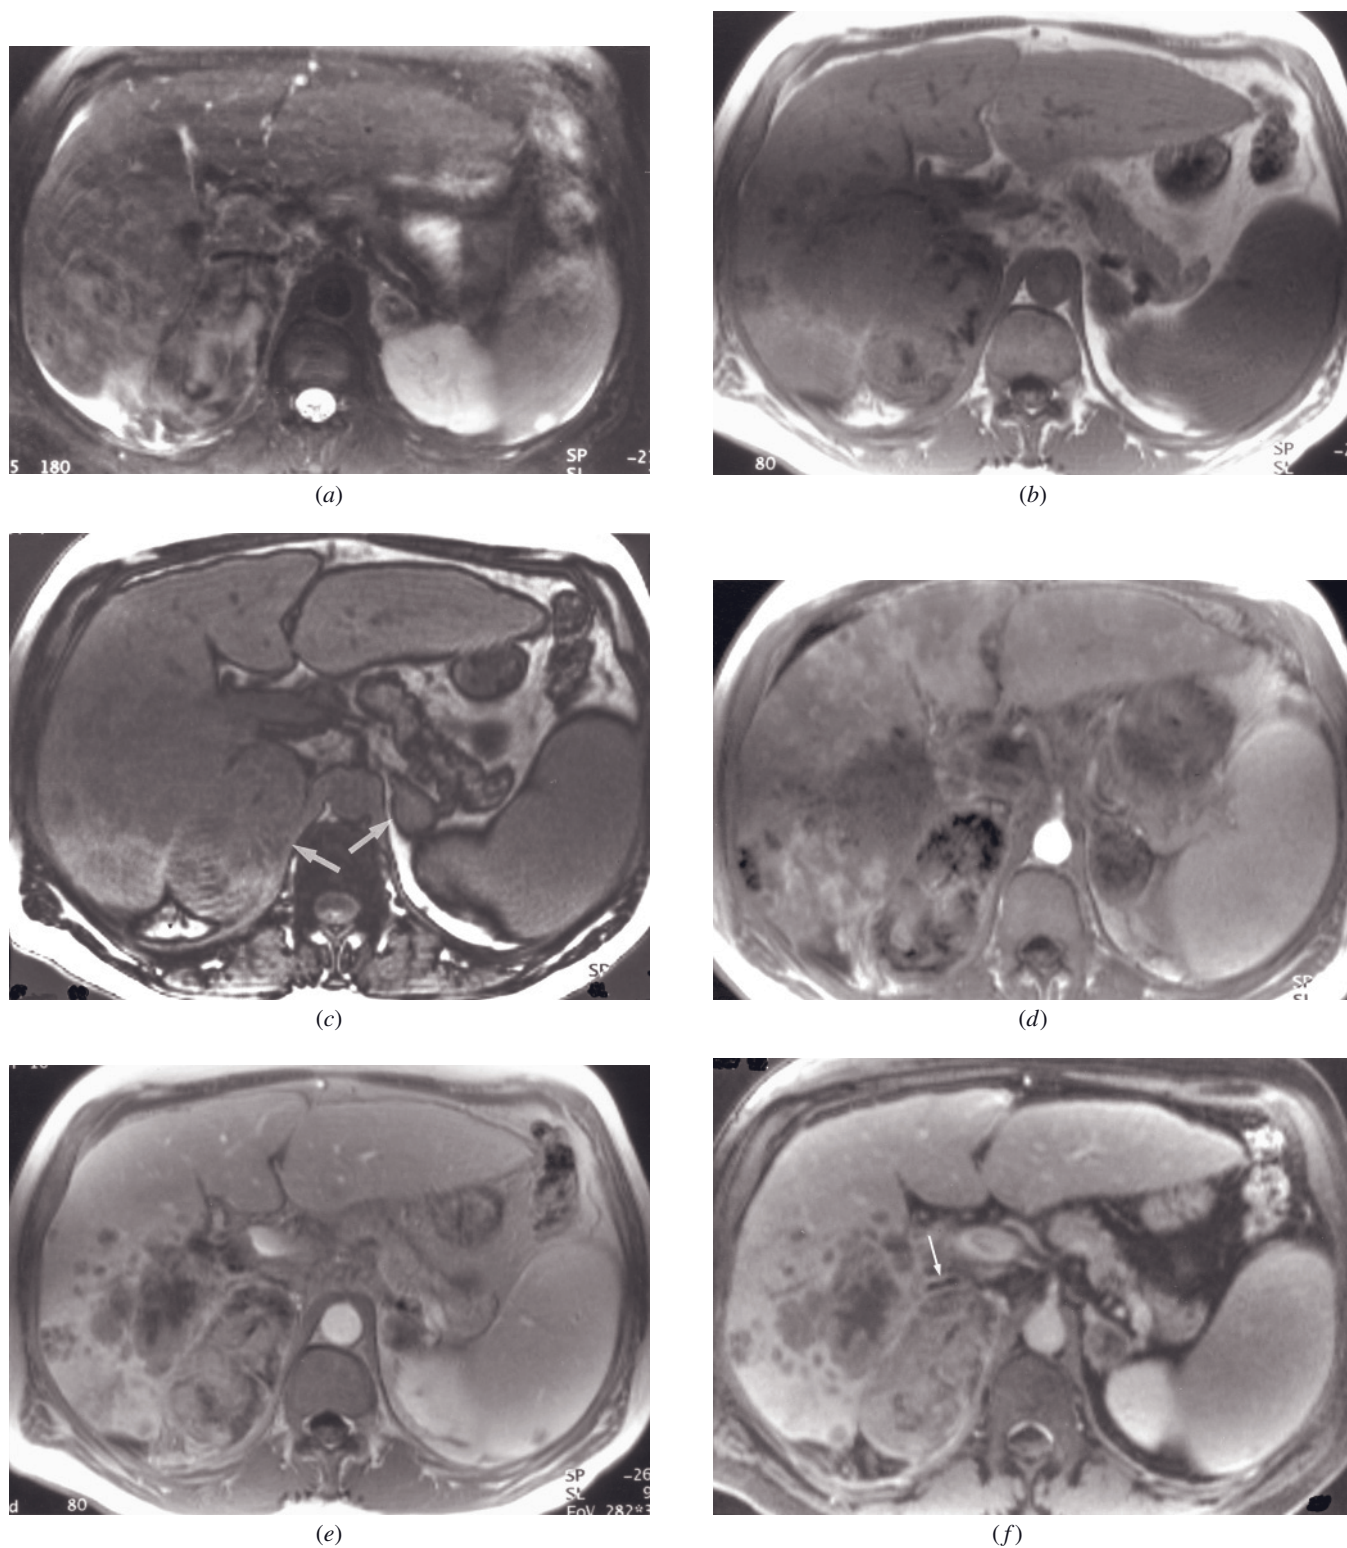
HCC and adrenal metastases. Fat-suppressed T2-weighted ETSE (*a*), SGE (*b*), out-of-phase SGE (*c*), and immediate (*d*), 45-s (*e*), and 90-s fat-suppressed postgadolinium SGE (*f*) images. There are multiple lesions throughout the liver, which are high signal on T2 (*a*) and low signal on T1 (*b*) and demonstrate a mixed population of lesions that enhance in a diffuse heterogeneous or peripheral ring fashion on immediate postgadolinium images (*d*), consistent with multifocal HCC. Ring enhancement in many of these lesions presumably represents intrahepatic metastases. Bilateral adrenal masses (arrows, *c*) are present that demonstrate mixed signal intensity on T1 (*b*), do not drop in signal on out-of-phase (*c*), and enhance heterogeneously after contrast administration (*d-f*) consistent with metastases. Abnormal signal in the IVC (arrow, *f*) represents thrombus.
